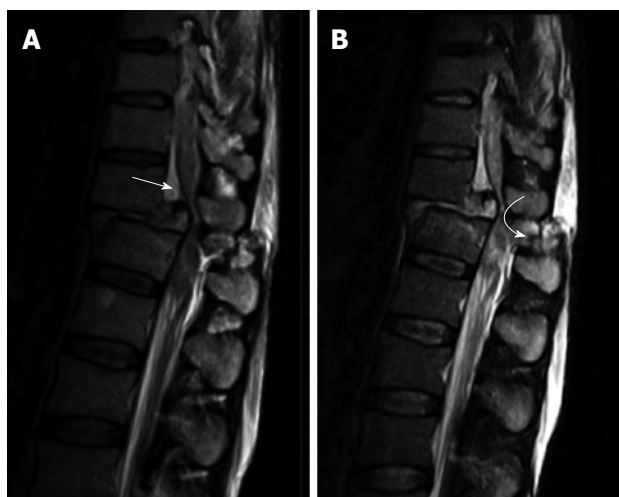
Magnetic resonance imaging in thoraco-lumbar injuries. T2 weighted sagittal magnetic resonance images showing cord compression (arrow in (A)) and disruption of Posterior Ligamentous Complex [curved arrow in (B)].
